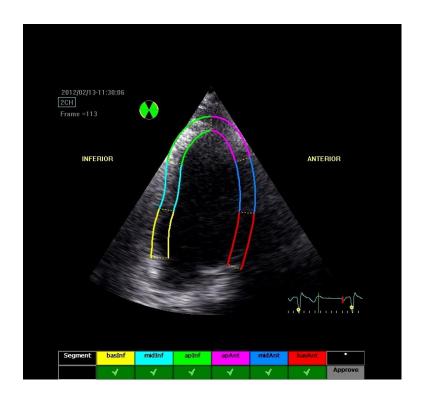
10 Automatic software grading of tracking quality for 2DST in apical 2-chamber view
